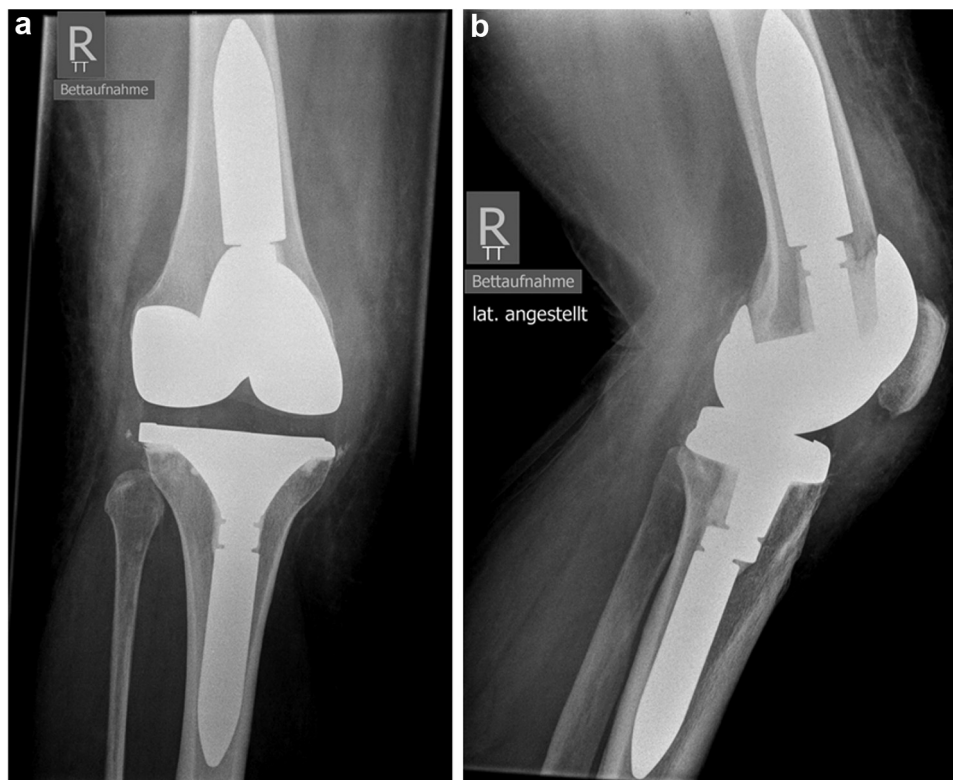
Anteroposterior (a) and lateral (b) radiographs of the right knee at admission. No signs of prosthetic loosening were found.
